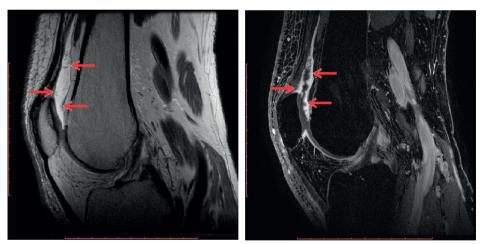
A sagittal MRI section of a T1 weighted MRI (left) and CE-MRI (right). Red arrows indicate location of inflamed synovial membrane.
